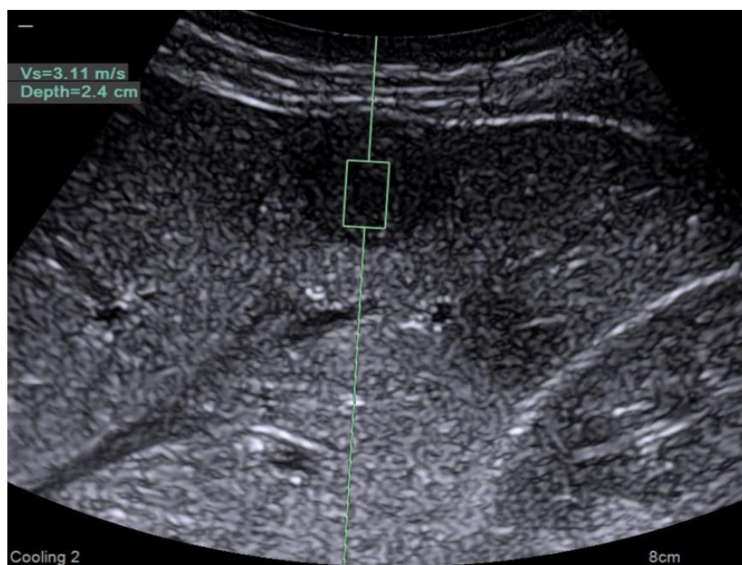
Ultrasound elastography in a metastasis
